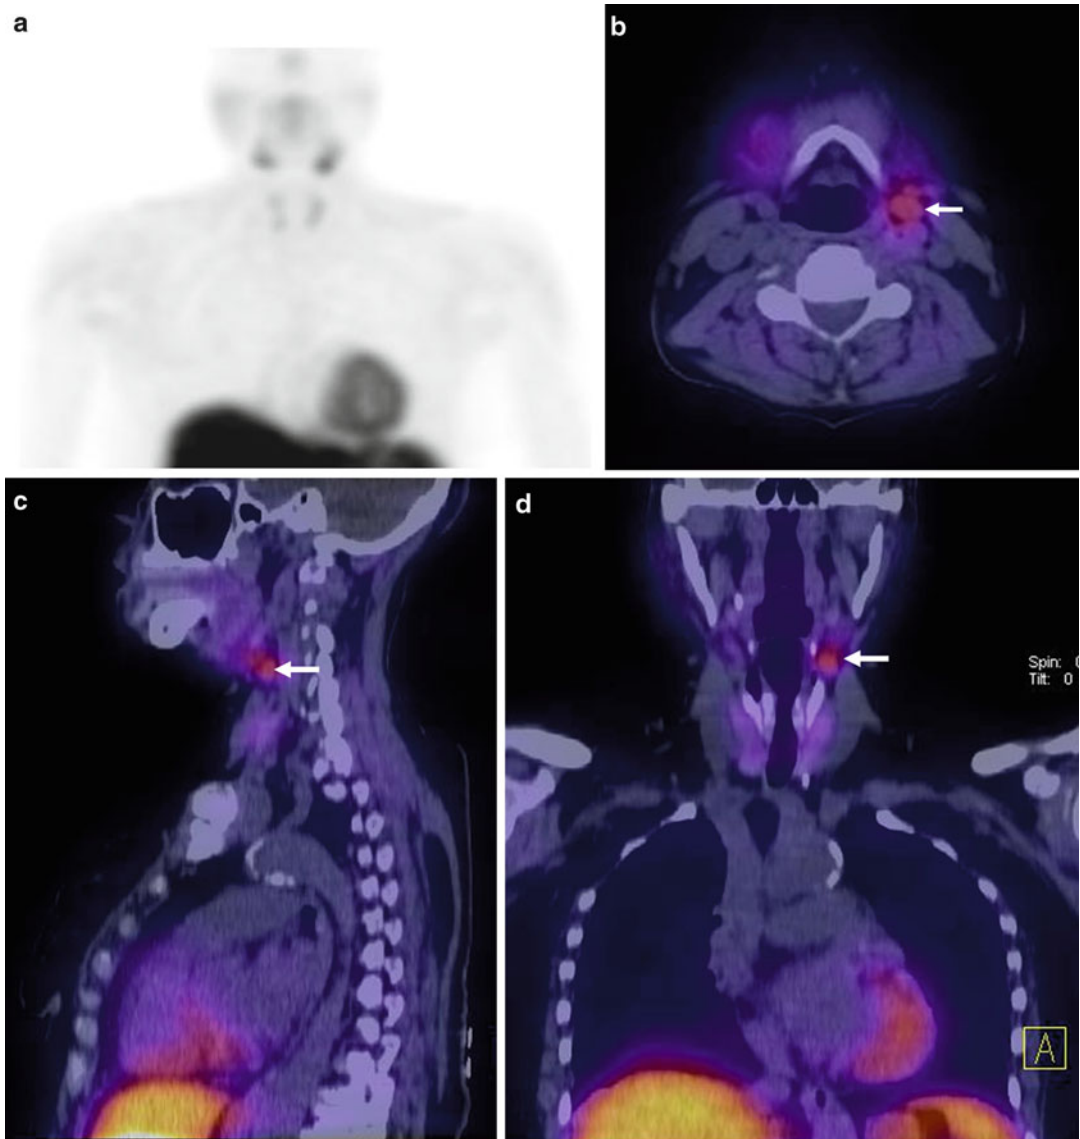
Undescended parathyroid adenoma. (a) Planar sestamibi scan appears relatively unremarkable. Sestamibi SPECT/CT demonstrates a sestamibi-avid soft tissue nodule
